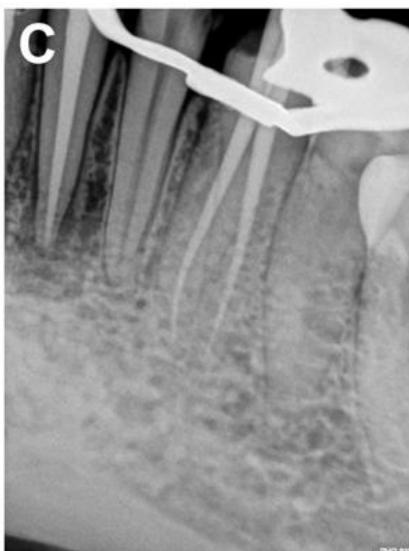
Check in radiograph showing seated master gutta-percha cones in both canals
